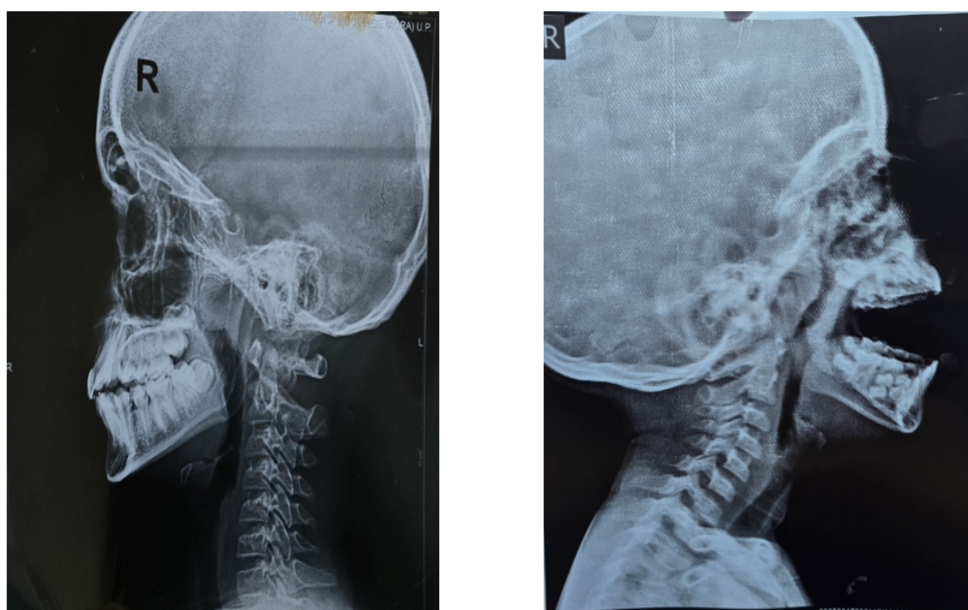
Lateral nasopharyngeal soft-tissue radiograph demonstrating adenoid hypertrophy
